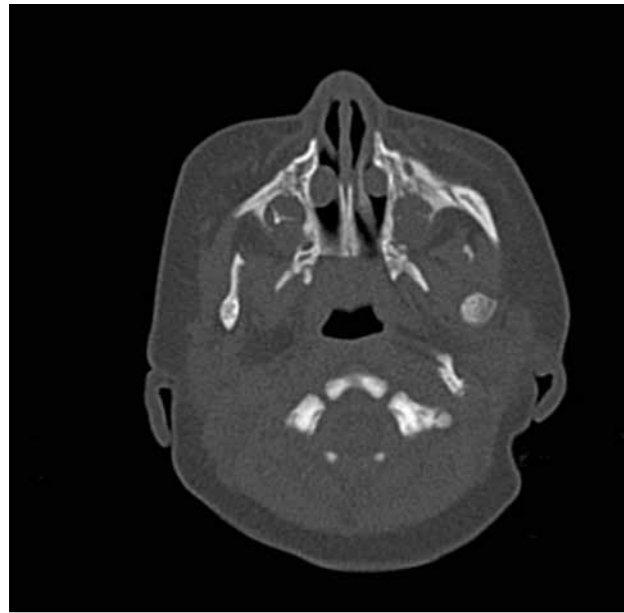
Axial CT scan demonstrating bilateral cystic swellings (dacryocystoceles) in the inferior meatus. The child presented with acute respiratory distress immediately after birth.
